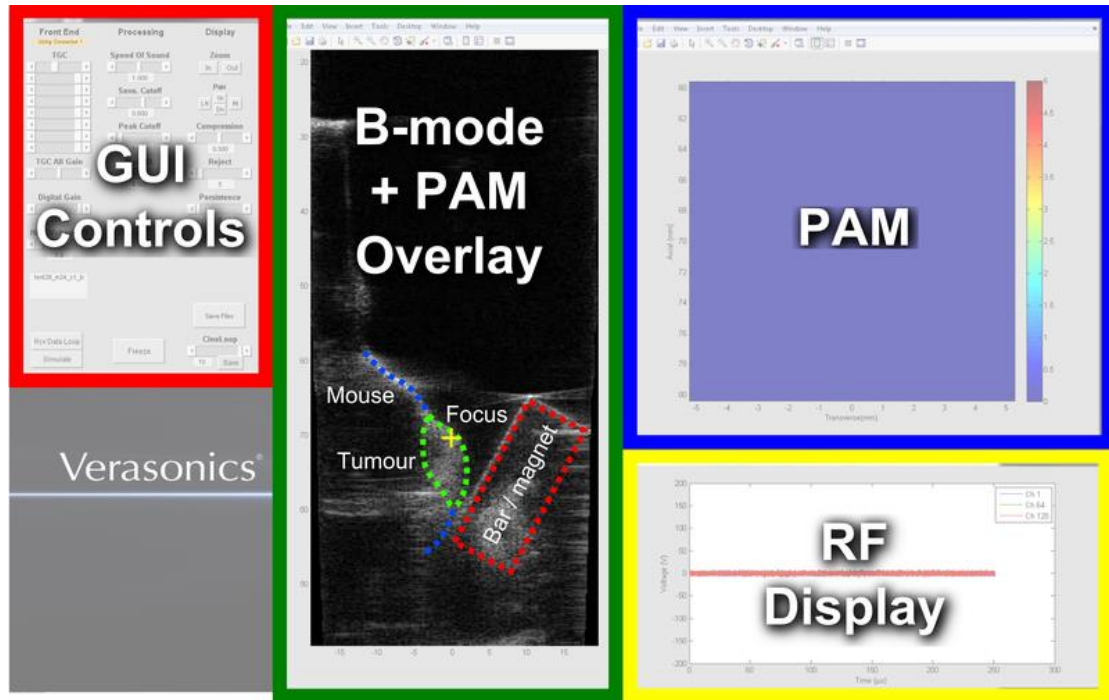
Ultrasound research platform real-time display for *in vivo* experiments (prior to activation of HIFU transducer) showing GUI controls, B-mode ultrasound image (annotated to show features), PAM standalone display (colourbar in units of power (AU)), and filtered RF data for selected channels (units in volts).
